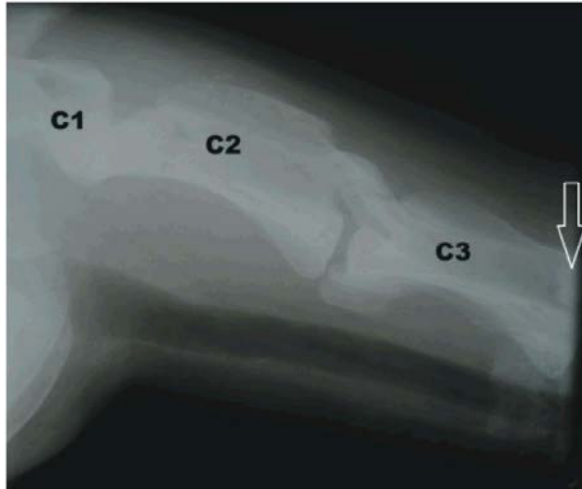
Lateral radiograph of the first 3 cervical vertebrae in a llama affected by fracture of the articular facet of the fourth cervical vertebra. Note the radiopaque bone fragment on the caudal area of the spinal canal of C3 (arrow).
